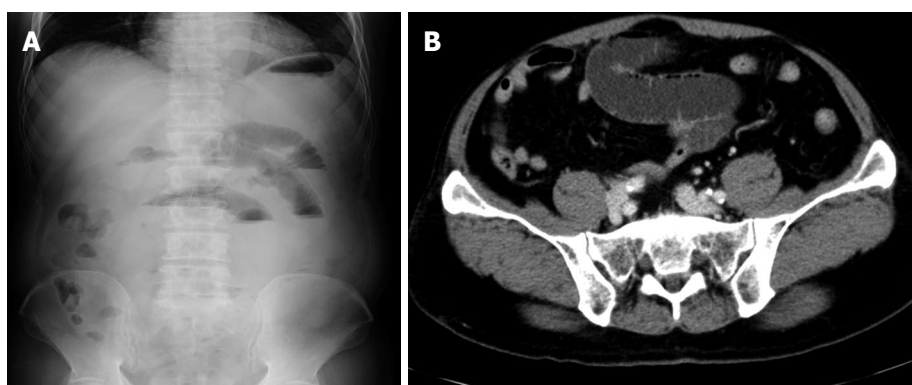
Abdominal X-ray (A) and computed tomography scan (B).
